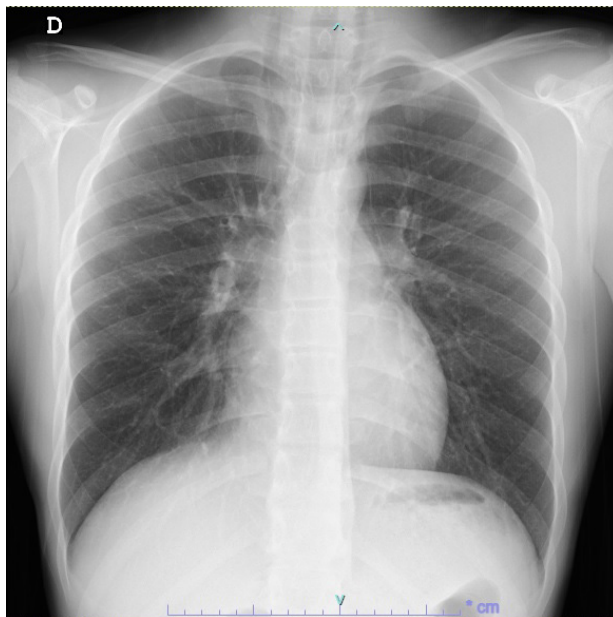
Follow-up posteroanterior chest radiograph after high-flow oxygen therapy demonstrating complete resolution of the previously observed pneumomediastinum, with disappearance of the paratracheal air columns.
